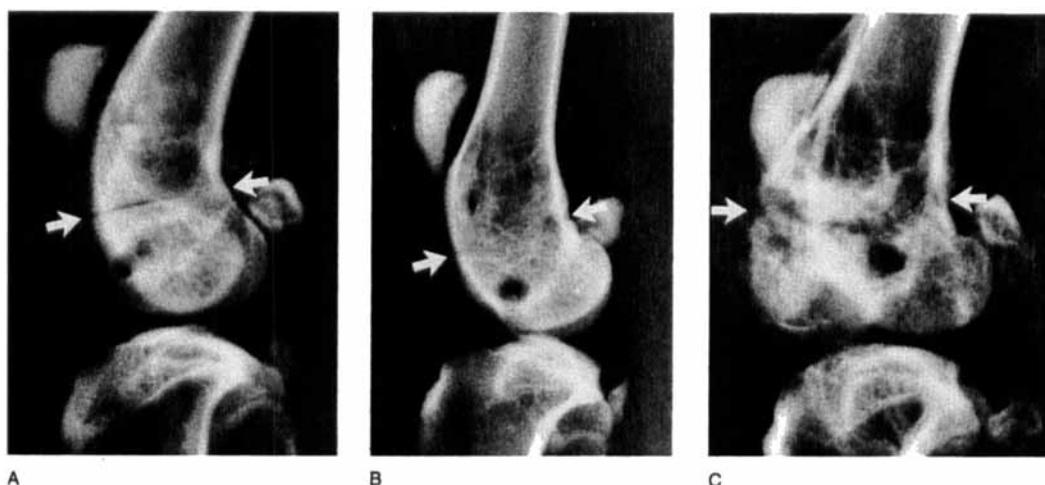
Radiographs of tibial osteotomies.
